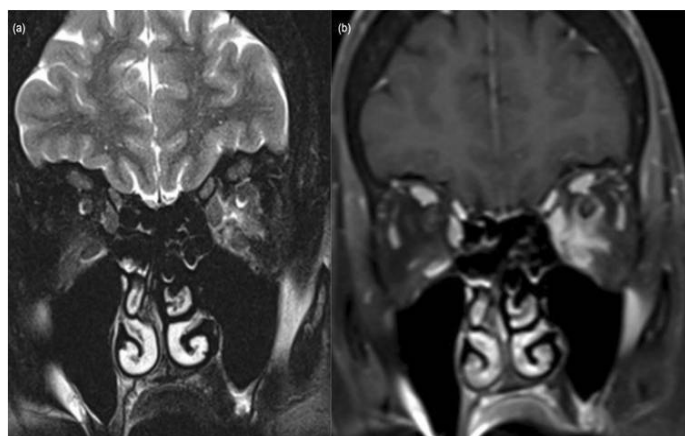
Orbit follow up MRI
